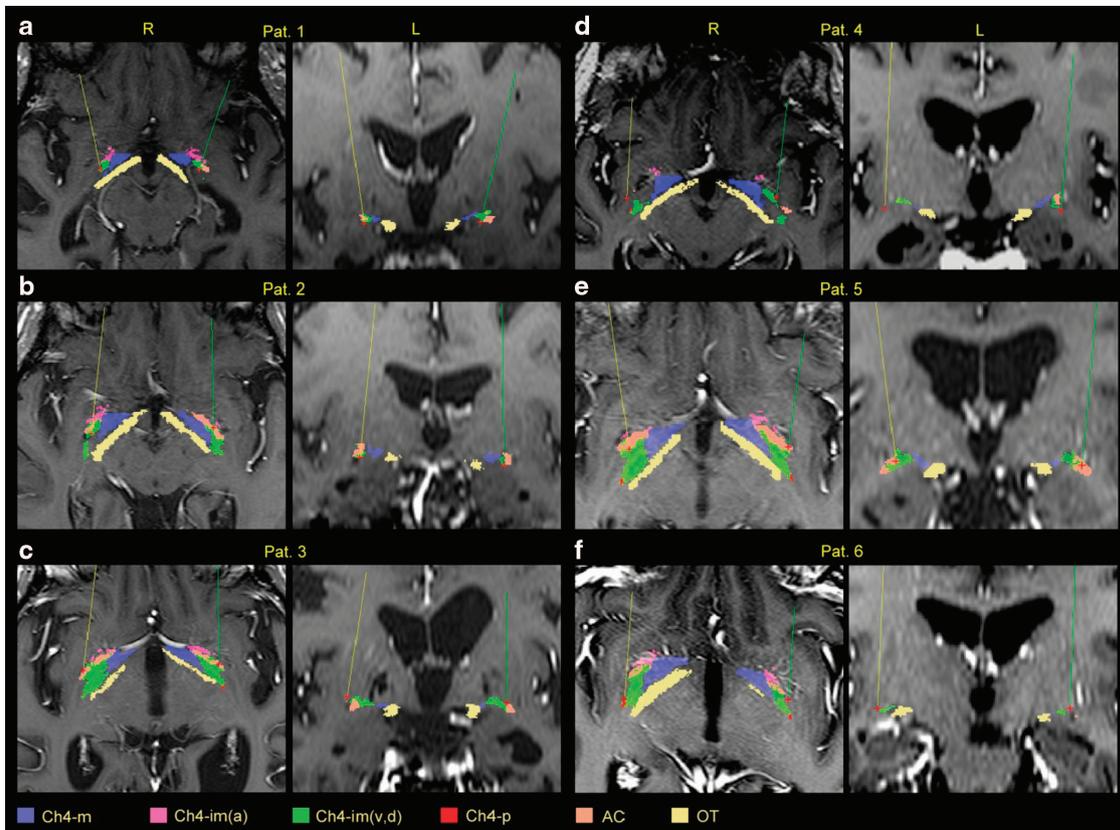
Localization of electrode position in the lateral and posterior portion of the NBM of the six patients. After the operation, electrode position was analyzed using a two-stage nonlinear multigrad atlas co-registration method that transformed the atlas information¹³ onto the individual patient's MRI. Ch4-m, medial NBM; Ch4-im (a,v,d), intermediate NBM with anterior, ventral and dorsal divisions; Ch4-p, posterior NBM; AC, anterior commissure; OT, optic tract.
